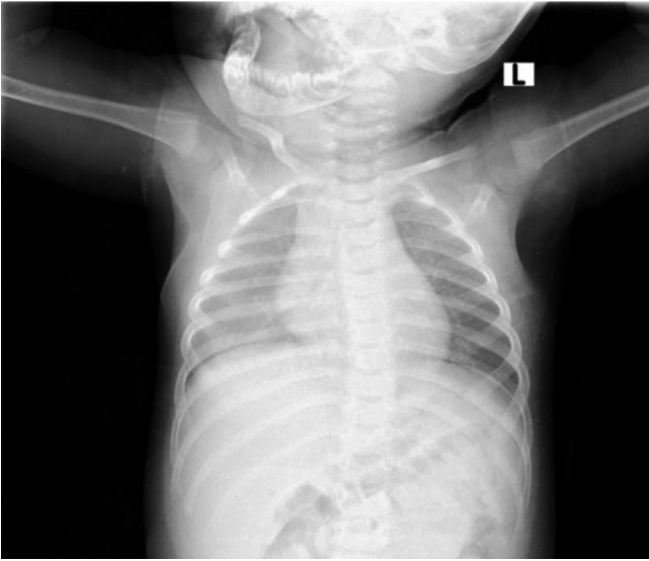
Anteroposterior chest radiograph depicts a hazy opacity veiled over the right hemithorax and ipsilateral scapular regions.
